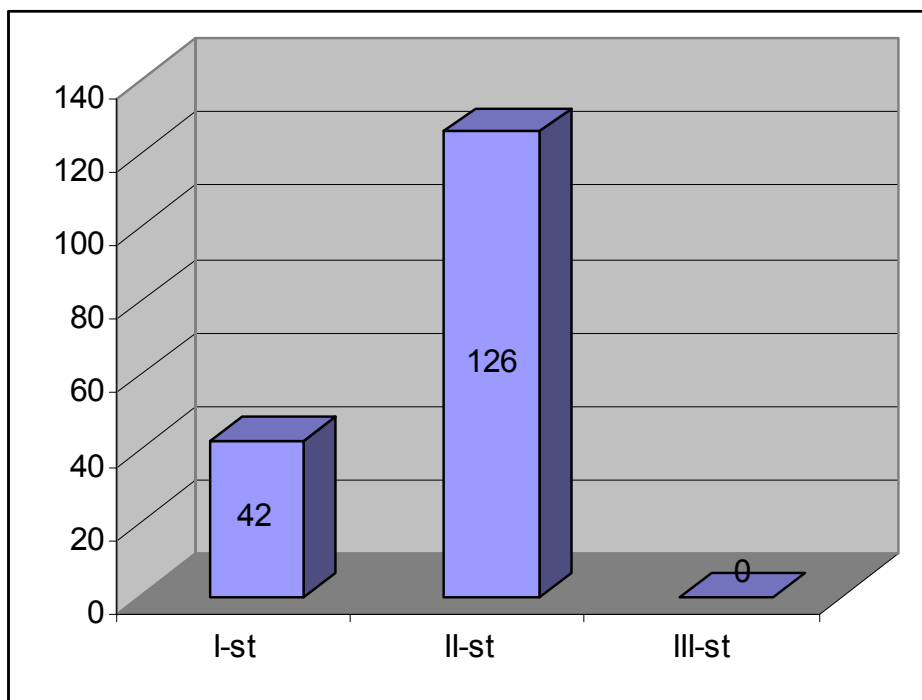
Endosonographic finding in operable group*
